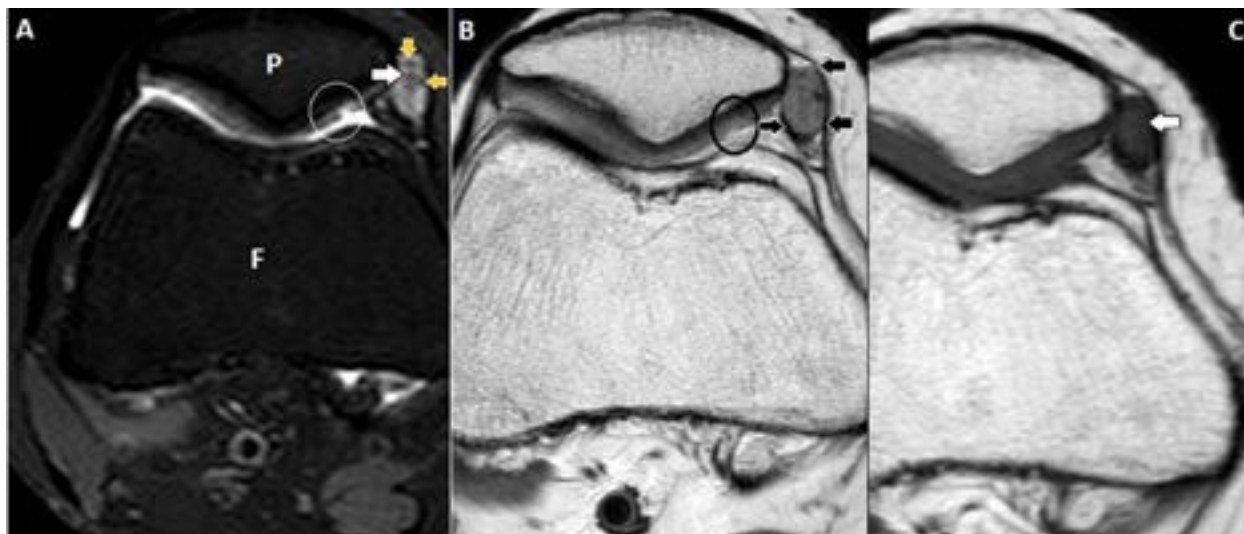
(A) PD (proton density) fat suppressed axial, (B) PD-weighted axial and (C) T1-weighted axial MR images confirm the PD hyper and T1 hypointense lesion (white arrows) in the medial deep soft tissue aspect adjacent to patella splitting the fibres of medial patellar retinaculum and medial patellofemoral ligament (black arrows). Prominent hypointense dots (yellow arrows) within the lesion suggest intra-lesional vascularity. Note the full thickness defect in the mid part of medial patellar cartilage (circles). P-patella, F-femur
